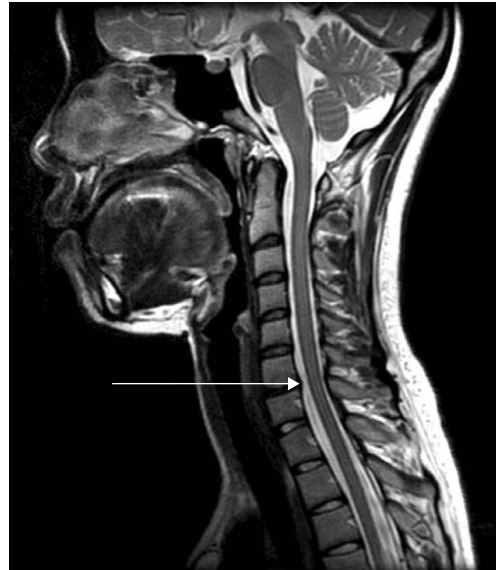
Magnetic resonance imaging of the cervical spine shows only a bulging disc at the C6/7 level with mild spinal stenosis. As the arrow indicates, the black-sigaled space between C6 and C7 is protruding into the white-sigaled spinal canal filling with cerebrospinal fluid.
